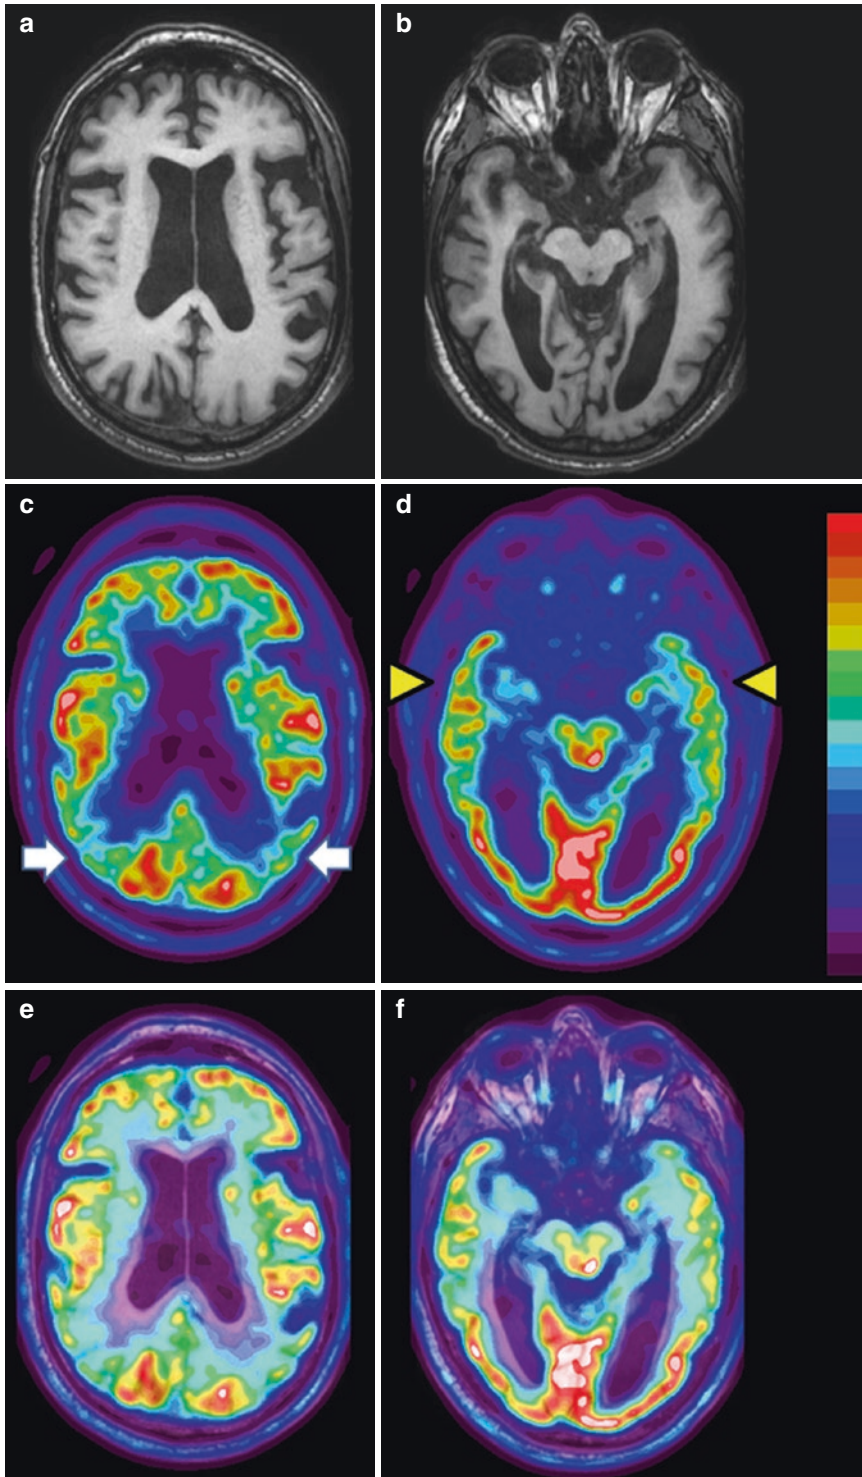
Brain $[^{18}\text{F}]\text{FDG}$ -PET in a patient with cognitive impairment. T1-weighted axial (a) and coronal (b) MR images, axial (c) and coronal (d) $[^{18}\text{F}]\text{FDG}$ -PET, and fused PET/MR images (e, f) demonstrate decreased $[^{18}\text{F}]\text{FDG}$
